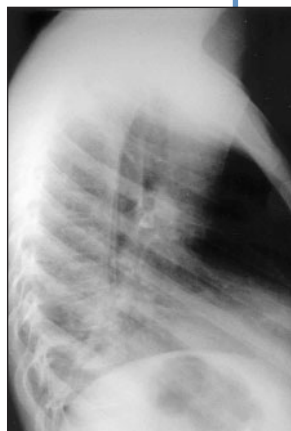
The molar is at the centre of this lateral chest radiograph; distal atelectasis is also apparent.
